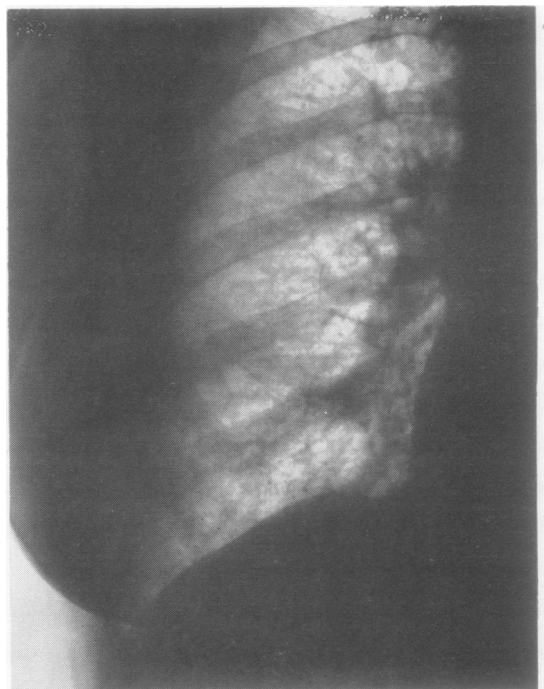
(Case 2).—Radiograph showing lower two-thirds of right lung field.
